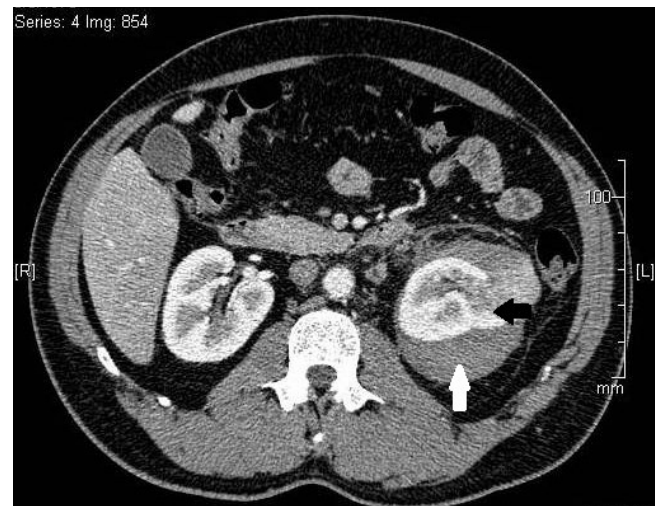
CT Urogram showing left renal mass (black arrow) and peri-nephric haematoma (white arrow)
